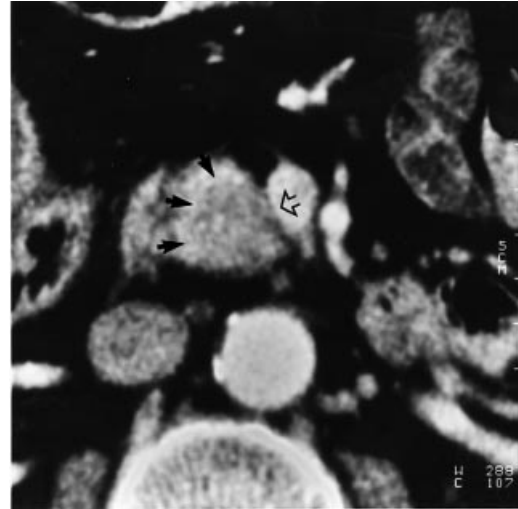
Small pancreatic head carcinoma (black arrows). Computed tomography grade C contact with superior mesenteric vein with flattening of the vein (open arrow). The lesion was radically resected; sleeve resection was necessary
